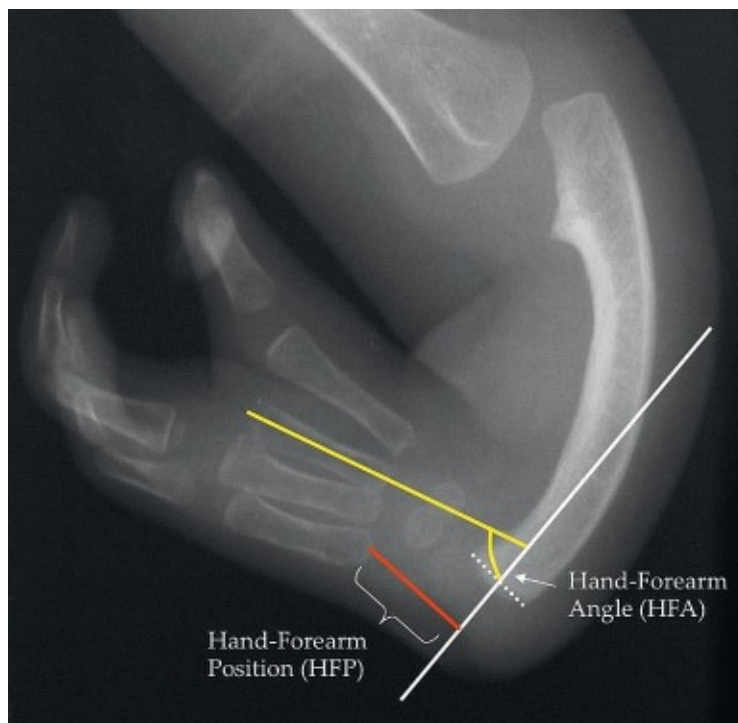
• Measuring hand-forearm angle (HFA) and hand-forearm position (HFP) on the plain radiograph.
